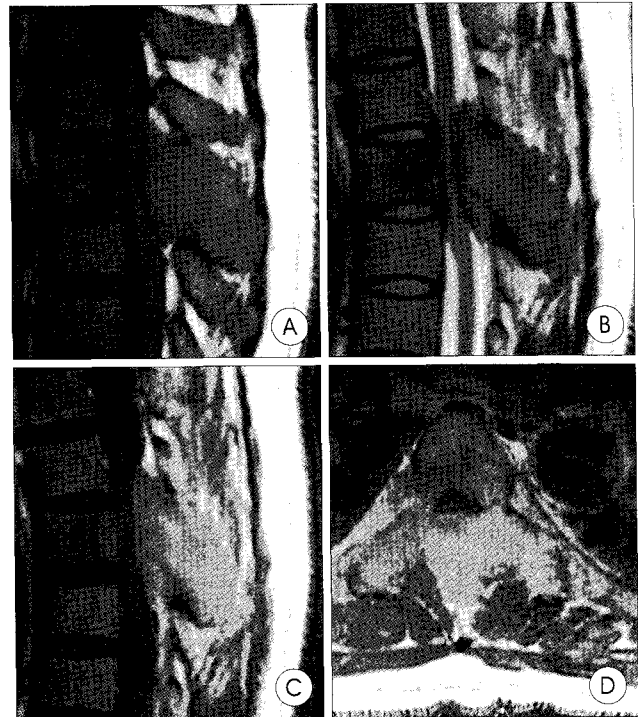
Sagittal magnetic resonance images of the thoracic spine showing a tumor mass of T6 : iso or slightly hyper intense on T1-weighted image(A), hypointense on T2-weighted image(B) and weak homogenous enhancement(C). The axial image after enhancement(D) shows the tumor mainly invaded the posterior and middle element of T6 compromising the spinal canal.
